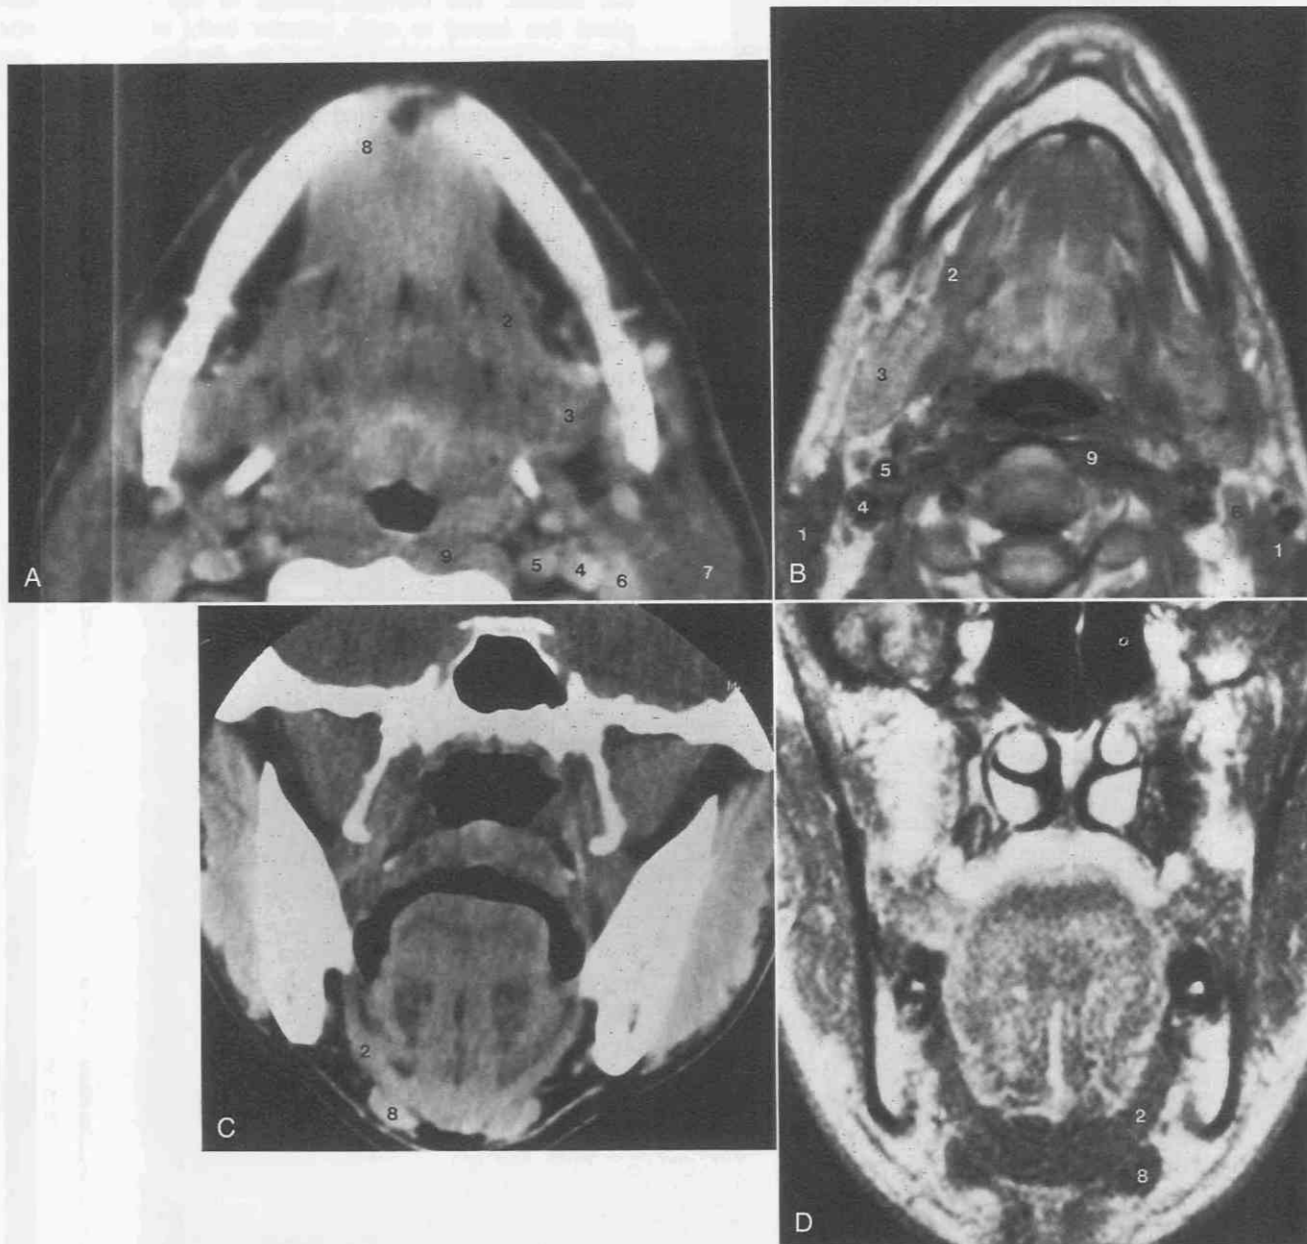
Normal sectional anatomy at the junction of the oral cavity and neck. A, Contrast-enhanced CT image at the level of the mandible. The sternocleidomastoid muscle is posterior to the parotid gland. B, T1-weighted MR image at a similar level in a different patient. Note the greater tissue contrast between the mylohyoid muscle and the submandibular gland on MRI. Coronal CT scan (C) and coronal T1-weighted MR image (D) demonstrate the anterior belly of the digastric inferior to the sling-shaped mylohyoid muscle. 1, Sternocleidomastoid muscle; 2, mylohyoid muscle; 3, submandibular gland; 4, internal jugular vein; 5, internal carotid artery; 6, posterior belly of digastric muscle; 7, parotid gland; 8, anterior belly of digastric muscle; 9, longus colli muscle.
